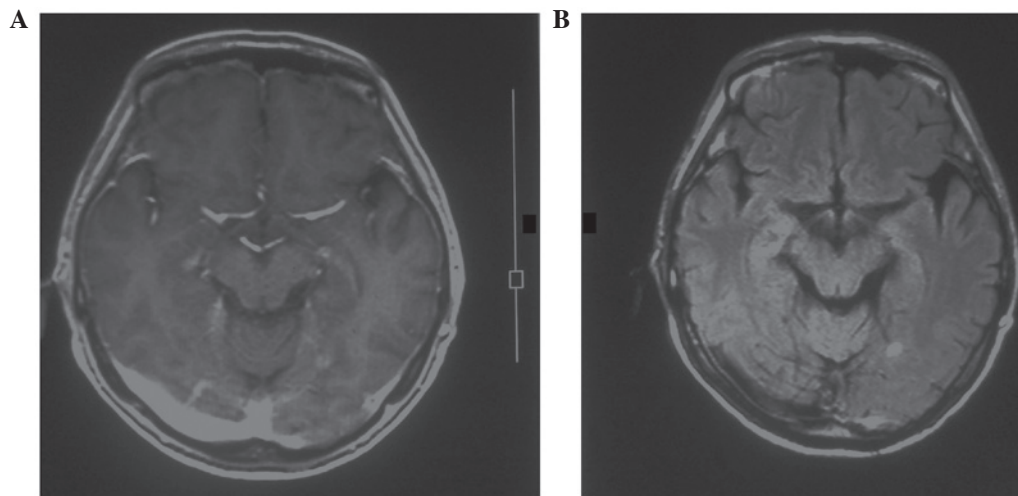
A metastatic lesion was identified in the left occipital lobe of the cerebral hemisphere during a follow-up magnetic resonance imaging scan. (A) Unenhanced scan. (B) Contrast-enhanced scan.
